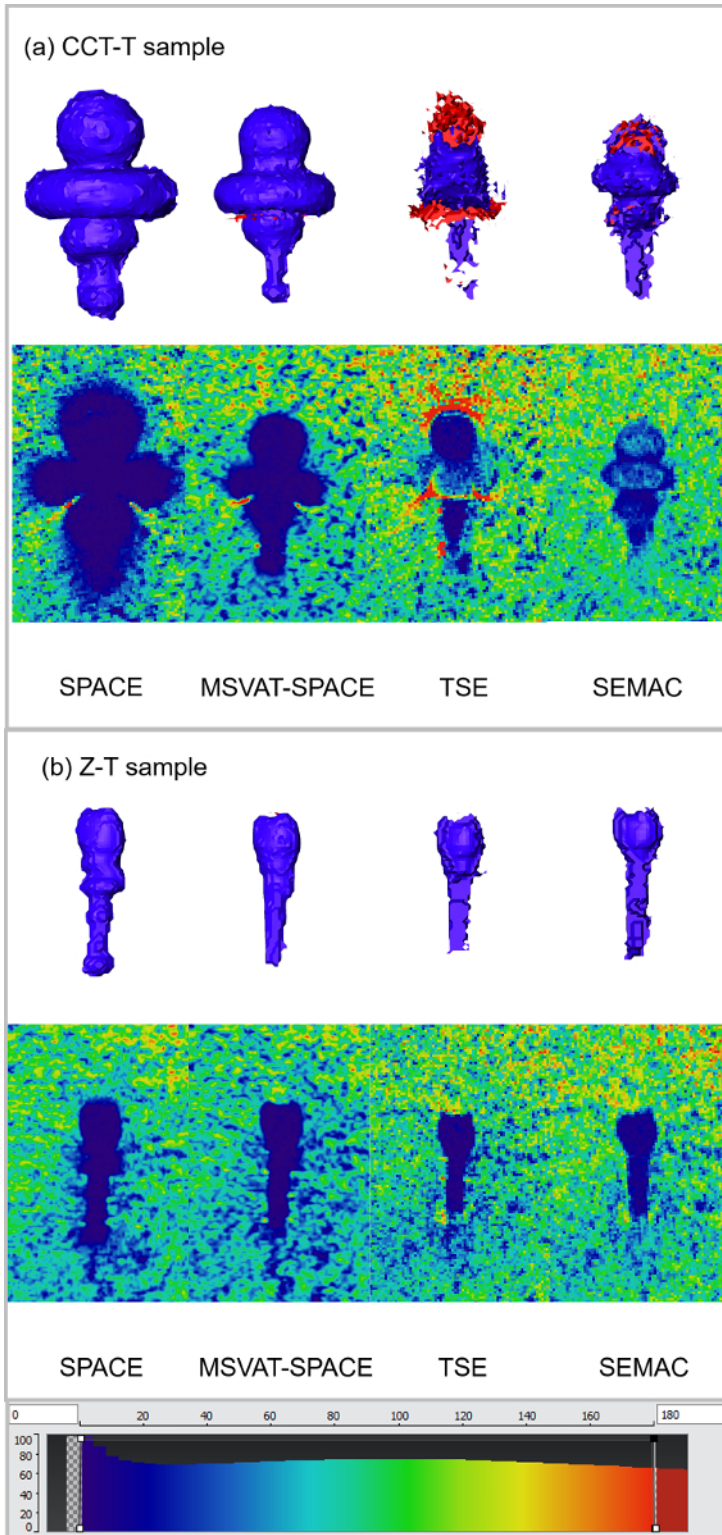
Appearance of artifacts. These panels render the artifact volumes of the entire implants (upper row). The blue colored areas represent signal loss artifacts and the red colored areas represent pile-up artifacts. The panels show the colored source images (lower row) for all evaluated T2-weighted sequences. Panel (a) is of the Cobalt-Chromium-Tungsten-Titanium (CCT-T) sample and panel (b) is of the Zirconia-Titanium (Z-T) sample. [Please click here to view a larger version of this figure.](#)
